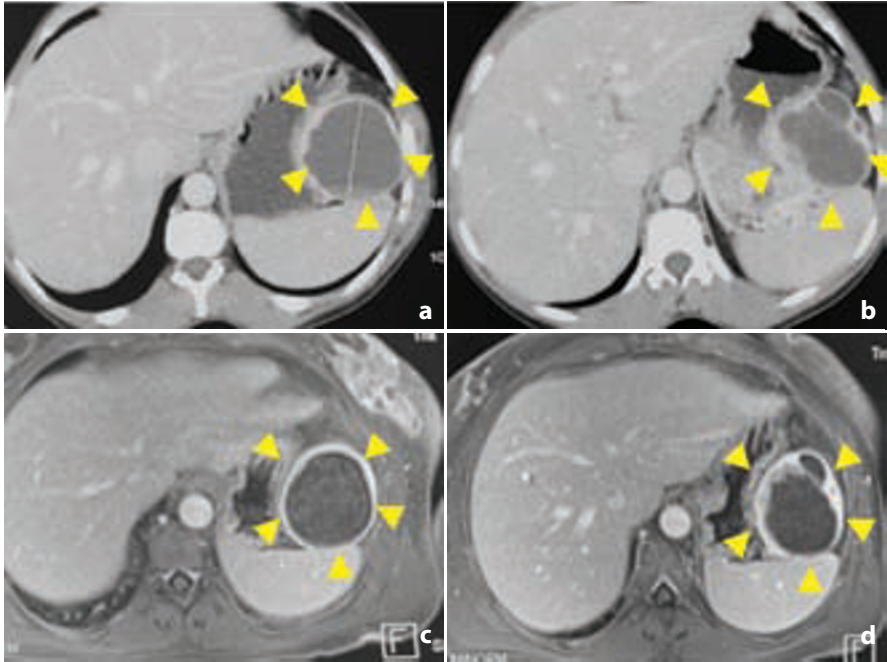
Cystic PanNEN studied using MDCT and MRI. A large cystic PanNEN of the pancreatic tail can be recognized on the axial images acquired during portal venous phase, both at MDCT (a, b) and at MRI (c, d). The ring-shaped pattern of enhancement (*arrowheads*) is better depicted on the latter. A differential diagnosis with other cystic pancreatic tumors cannot be obtained in this case
